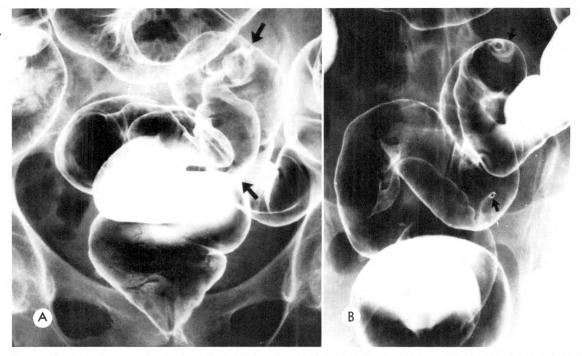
Roentgenograms showing two pedunculated polyps. A hemostasis clip is attached to the more distal polyp. (A) Anteroposterior view. (B) Angled view.
